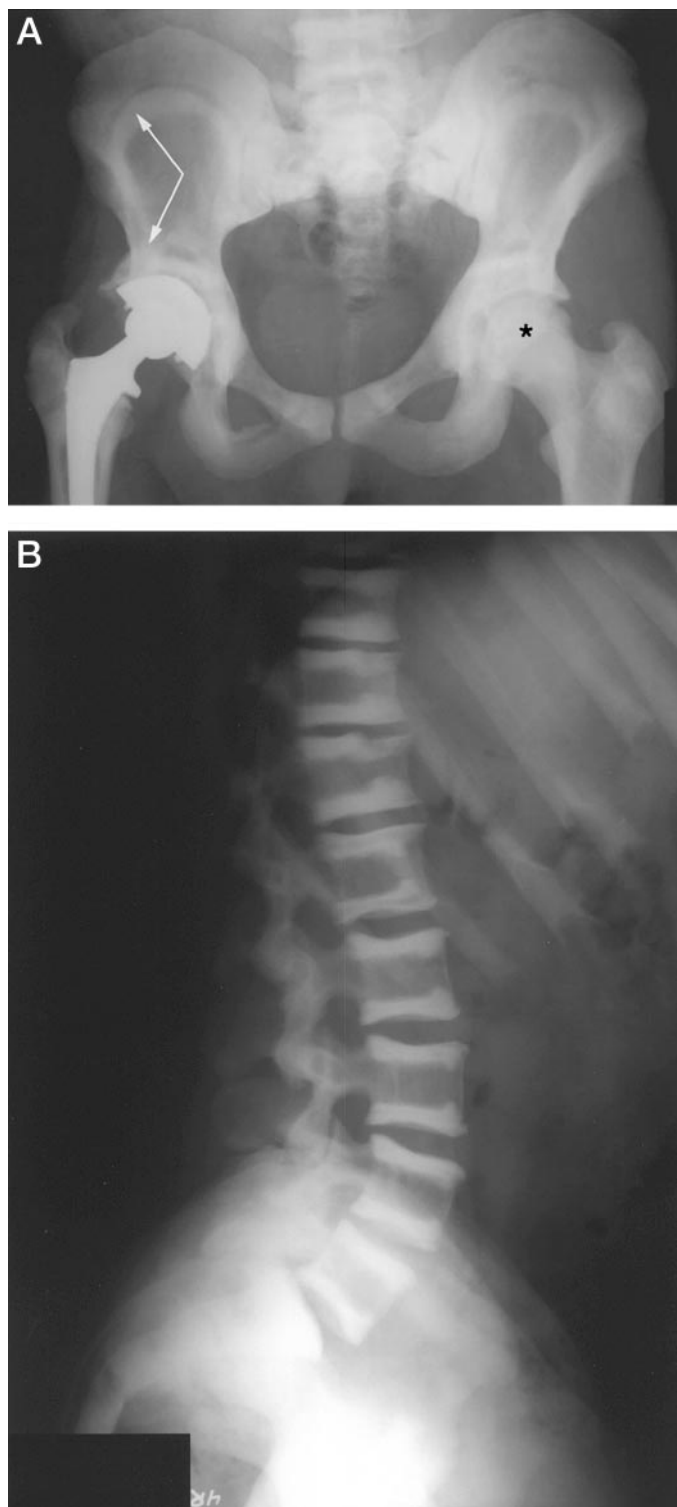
Classic radiographs of ADO2. A, Pelvic radiograph in a 27-yr-old patient. Note the typical findings of osteosclerosis and endobones within the pelvis (*arrows*) and proximal femur (*asterisk*). B, Lateral x-ray of the lower spine in a 47-yr-old patient that demonstrates the appearance of a rudder-jersey spine.
